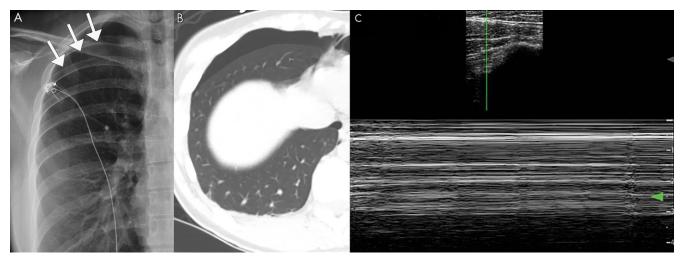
Pneumothorax on lung US. A, Posteroanterior chest radiograph and B, axial CT image of a spontaneous pneumothorax in a 26-year-old patient. C, M-mode US image shows the barcode sign, in which the smooth horizontal lines corresponding to the stationary chest wall are uninterrupted owing to lack of lung sliding, which is diagnostic for pneumothorax. Cine clips show absent lung sliding in the right lung (Movie 5) and the normal lung sliding in the left lung (Movie 6), which cannot be appreciated on still imaging. Arrows indicate location of the pleura in the setting of a pneumothorax.
